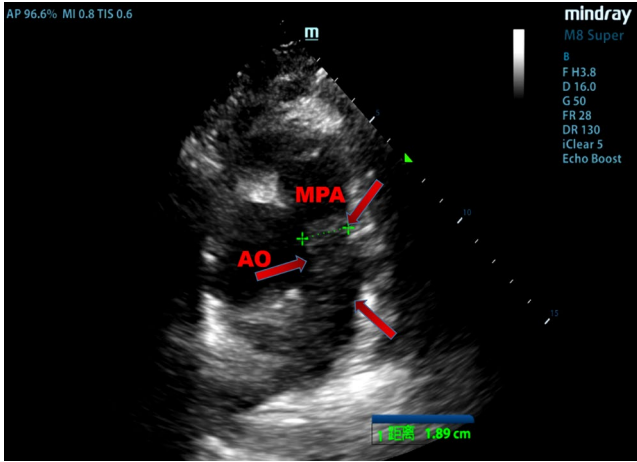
Pulmonary artery thromboembolism in a patient with COVID-19. Legend: Using remote consultation over bedside transthoracic echocardiography (RC-B-TTE), a mass with moderate intensity echo located in the main pulmonary artery of a critical COVID-19 patient (arrow) was discovered. The diagnosis of “pulmonary artery thromboembolism” had been missed by the frontline echocardiographer. AO, aorta; MPA, main pulmonary artery
